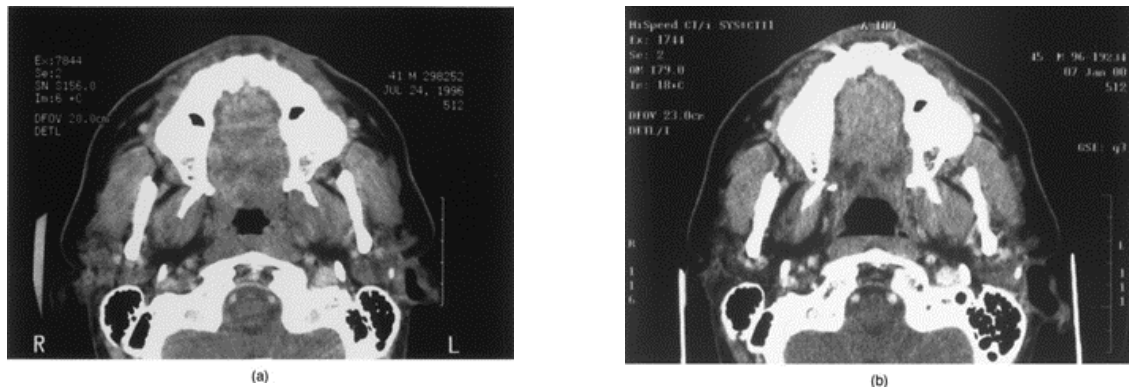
Axial CT scans in the reference plane (a) pretreatment (b) 3.4 years after 66 Gy in 33 fractions to the right side with a wedge pair technique showing 11% masseter atrophy and 28% medial pterygoid atrophy. [17]
